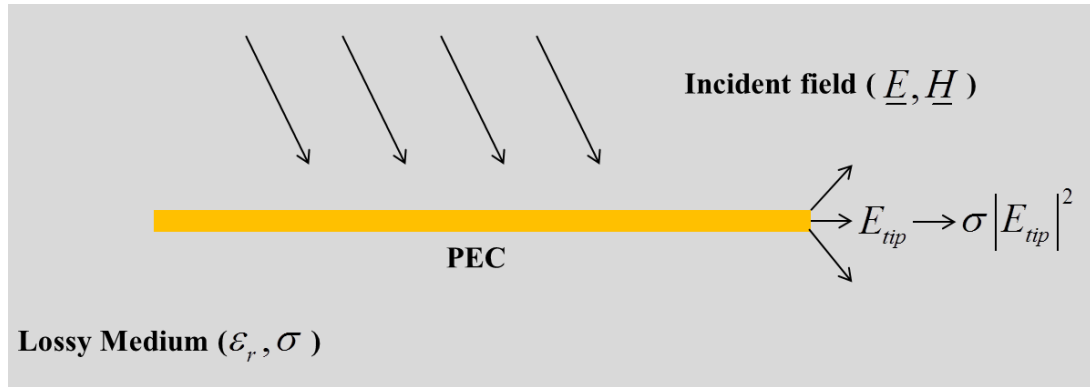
Simplified model for leads structure in MRI RF coil.
